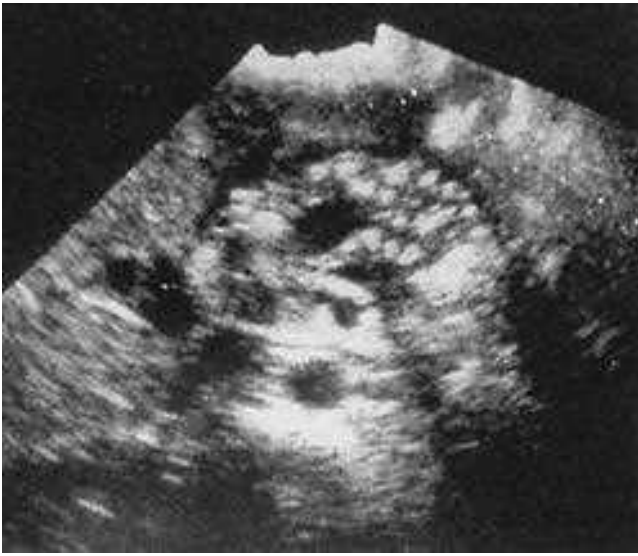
Sonography in chronic pancreatitis. Transabdominal sonogram of patient with chronic pancreatitis demonstrates heterogeneity of the pancreatic parenchyma, dilated ductal systems, and cyst formation. (Reproduced with permission from Bolondi et al. *Radiol Clin North Am.* 27: 815, 1989.)
